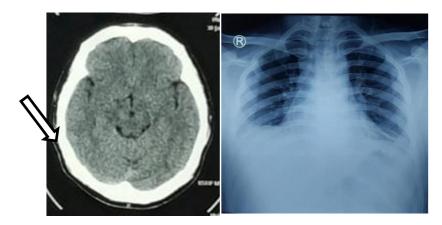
(a,b); (a) Axial section of CT scan: minimal perifocal oedema in left frontal region; (b) chest x ray: normal.
